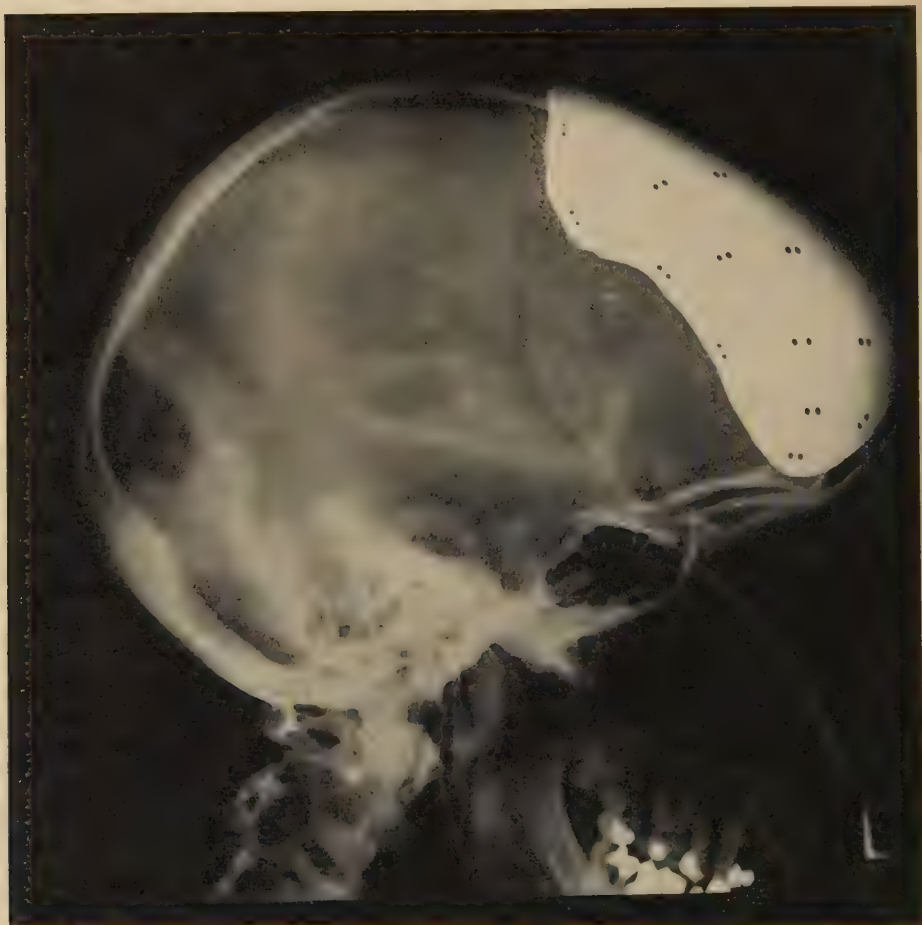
X-ray photograph of skull—lateral view.
